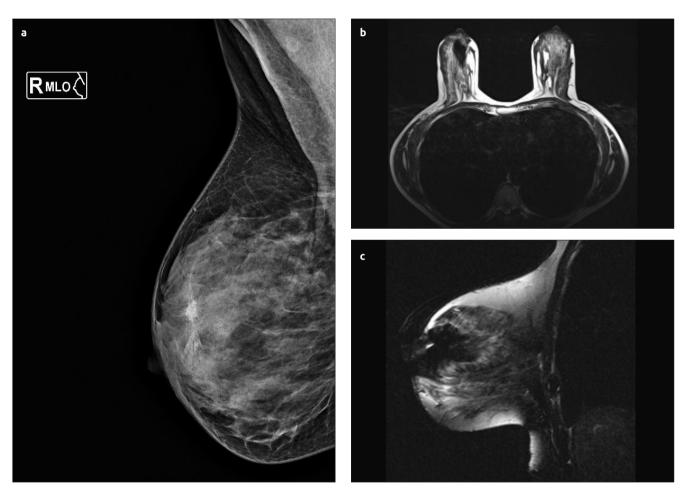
a-c. Postop mammography. Right MLO images. A spiculated density is seen on the right upper breast (a). Postop MRI. Axial and sagittal T2 weighted TSE, non-fat saturated image. A prominent susceptibility artefact is obscuring the right breast (b, c)
